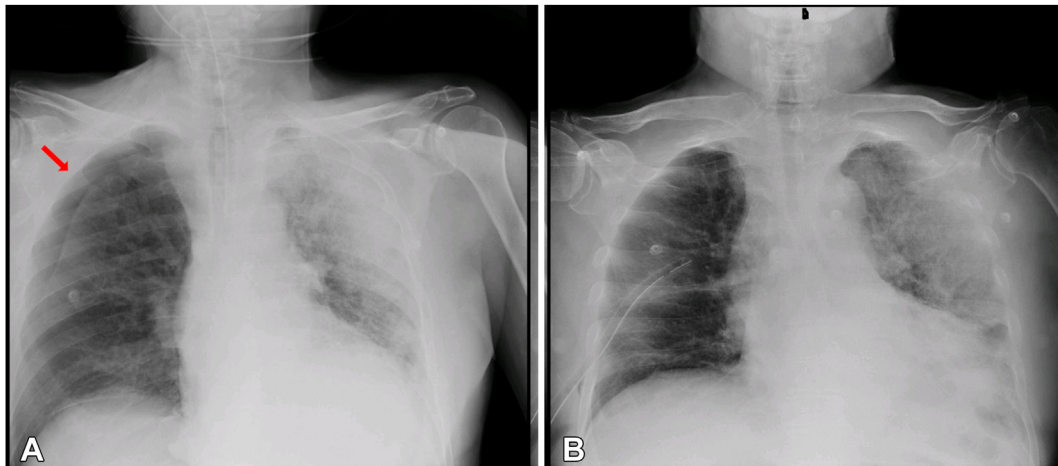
Chest x-ray examinations during procedure (time 0). A, Right pneumothorax (*red arrow*) and diffuse opacity of the left lung from massive bleeding. B, Resolution of pneumothorax after drainage insertion.
